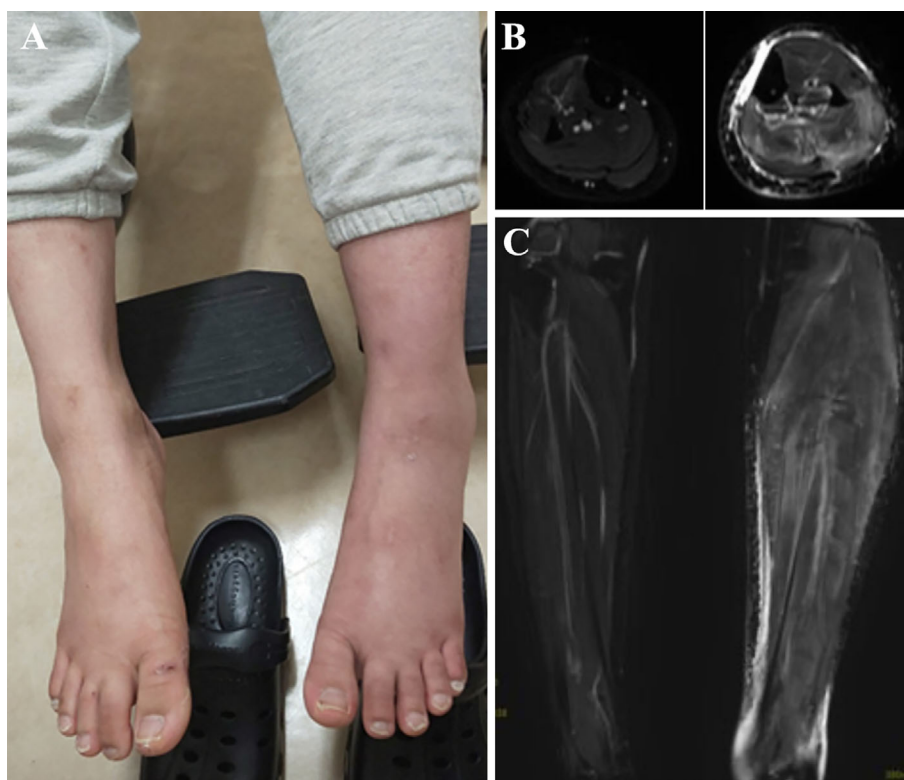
(A) Left-sided predominant edema of the lower legs. Muscle hypertrophy and fascial thickening of the left lower leg region detected by an (B) axial and (C) coronal view of short-tau inversion recovery on magnetic resonance imaging (MRI).
